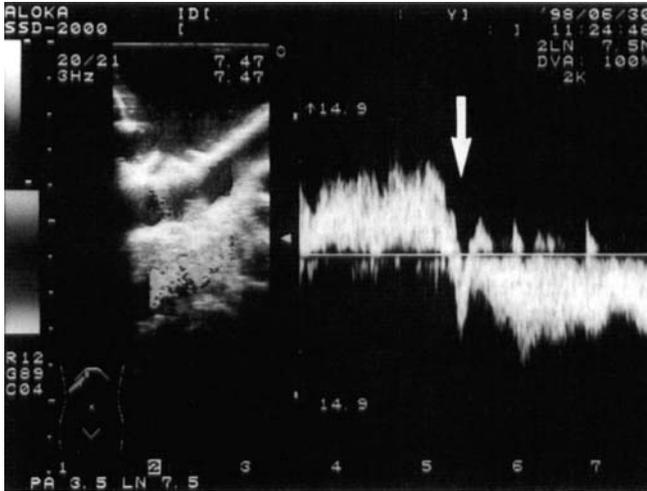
Intraoperative color Doppler ultrasonography shows hepatoportal blood flow, which is corrected to hepatopetal blood flow by clamping the shunt vessels (*arrow*)
